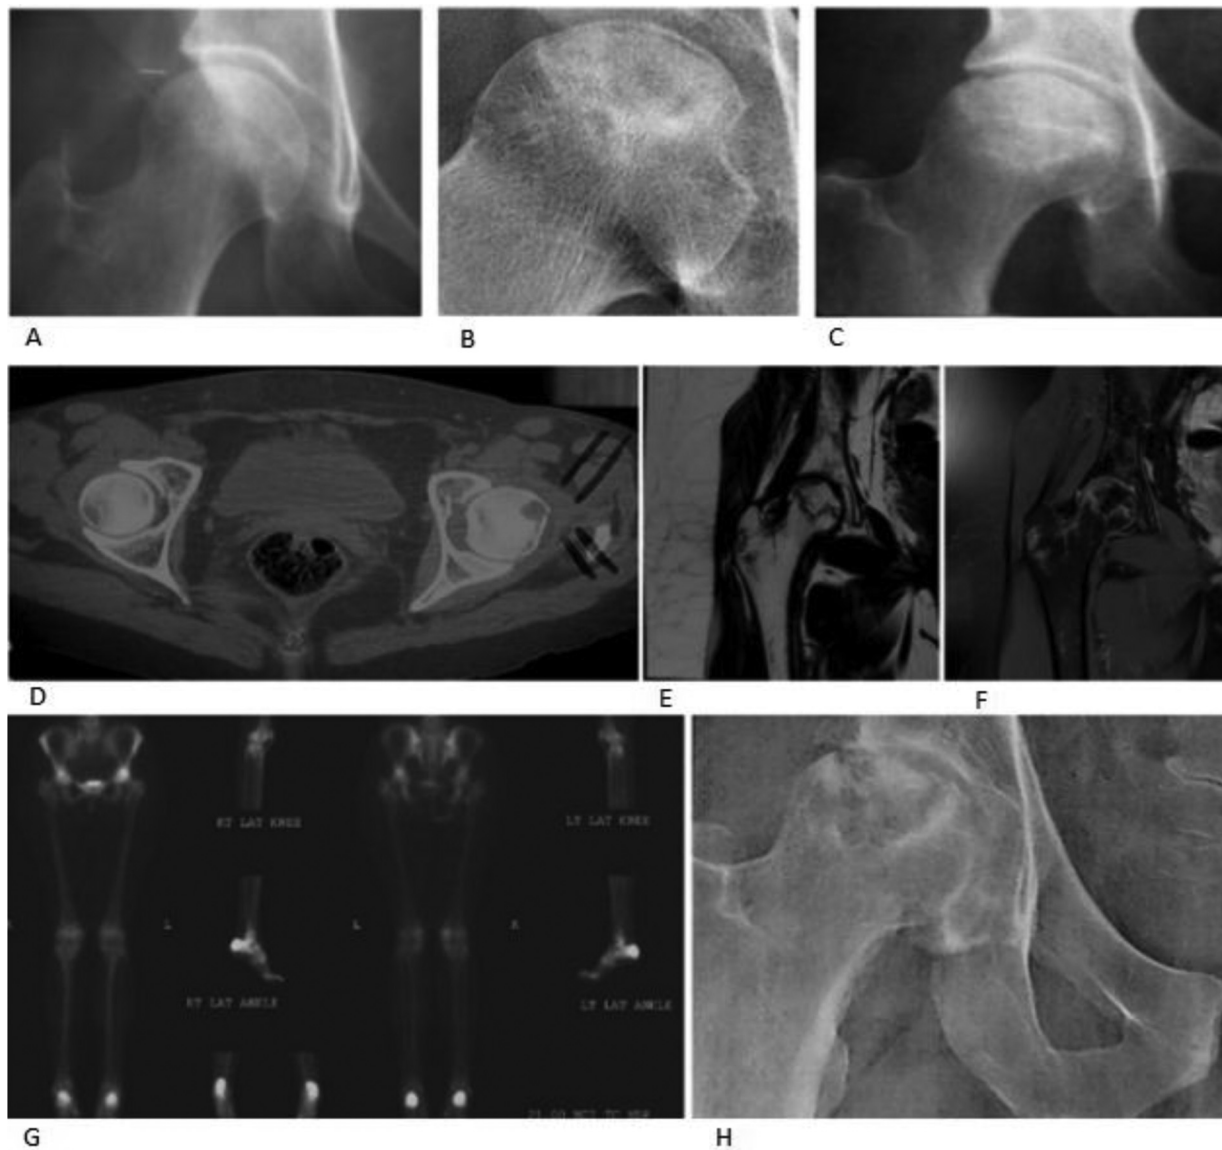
(A) Normal hip radiograph; (B) crescent sign; (C) flattening of the head; (D) tomography with head necrosis; (E,F) resonance with T1- and T2-weighted images with necrosis; (G) bone scintigraphy of the femoral head; (H) secondary degenerative changes.
